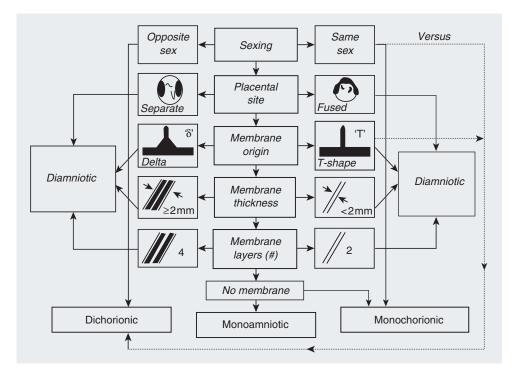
Several sonographic markers are available for assessment of chorionicity and amnionicity in the second and third trimesters. This algorithm can be used to make such an assessment
